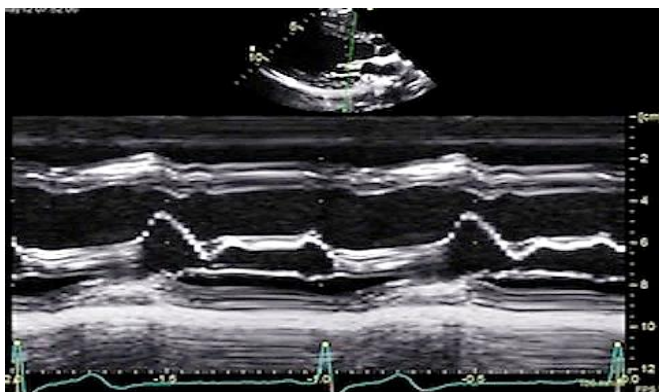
One-dimensional M-mode echocardiography of mitral valve.
